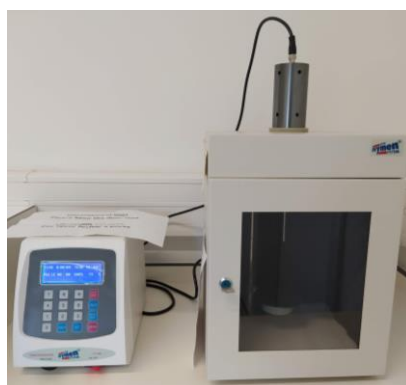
Ultrasonic homogenizer used for ultrasound-assisted extraction technique.
